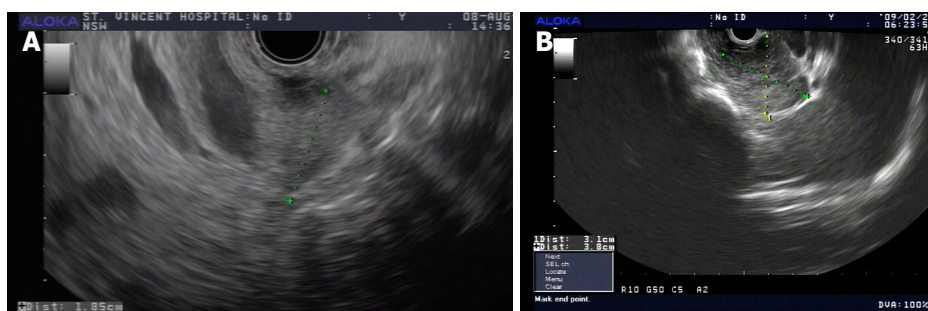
Endoscopic ultrasound images of (A) a small pancreatic adenocarcinoma in the head of the pancreas (1.8 cm) not seen on other modalities; and (B) a 3.1 cm pancreatic adenocarcinoma in the tail of the pancreas.
